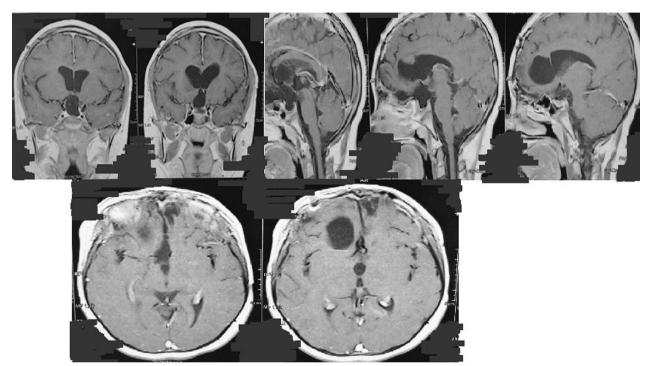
Post-operative MRI of patient 1
